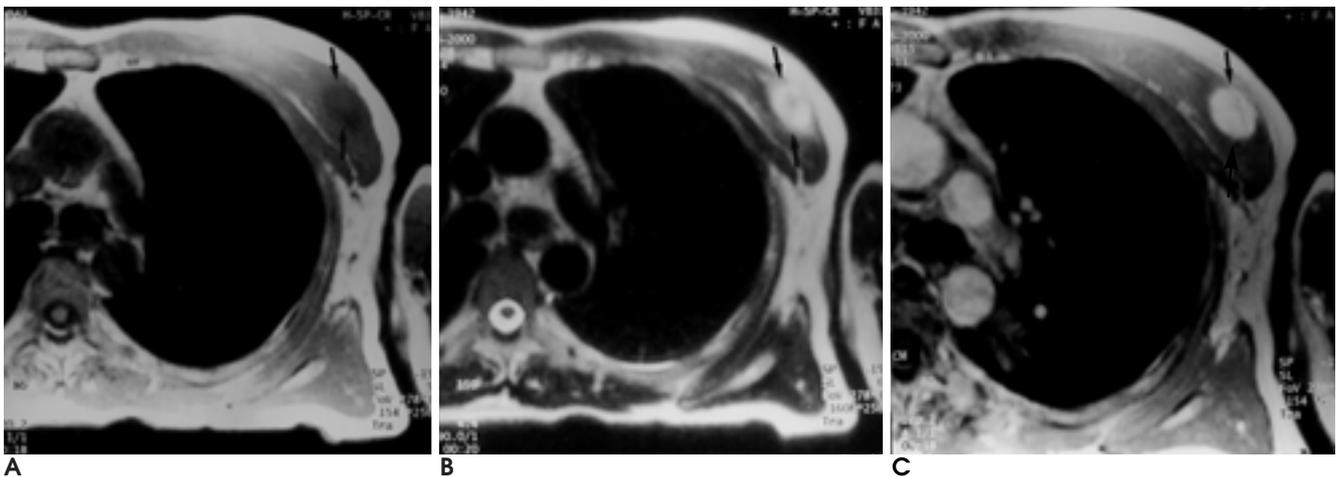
A. Axial T1-weighted image shows an ovoid, target like hypointense mass in the left pectoralis major muscle (arrows).
